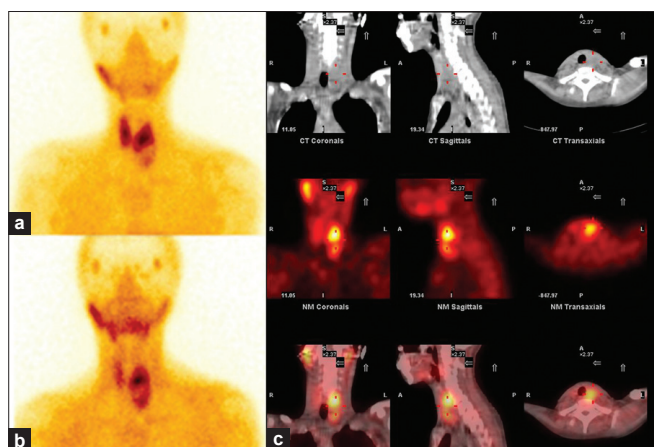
A 50-year-old female presented with hypercalcemia and raised PTH. (a) Tc99m sestamibi scan shows a photopenic area inferior to the left lobe of the thyroid with tracer uptake in the periphery in the form of a rim and uniform tracer uptake in both lobes of the thyroid. (b) Delayed images show washout of the tracer from both lobes. However, retention of the tracer is noted in the periphery of the photopenic area inferior to the left lobe of the thyroid gland. (c) SPECT/CT images show a cystic lesion, posterior to the left lobe of thyroid, whose periphery shows tracer uptake. A parathyroid cyst was found at surgery
